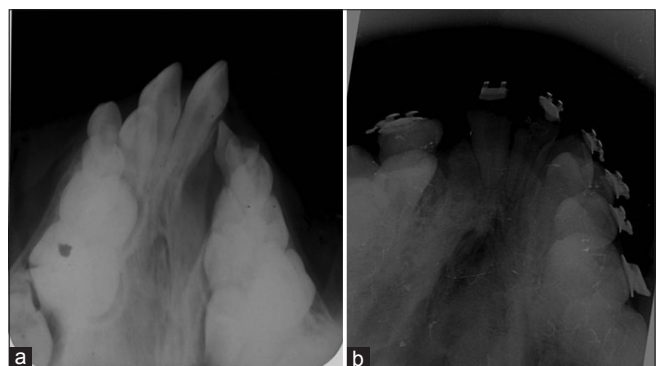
(a) Occlusal radiograph before secondary bone grafting. (b) Occlusal radiograph after bone grafting. The comparison of occlusal radiographs, before and after bone grafting, reveals the structural difference on the alveolar ridge, assigned to the bone grafting
